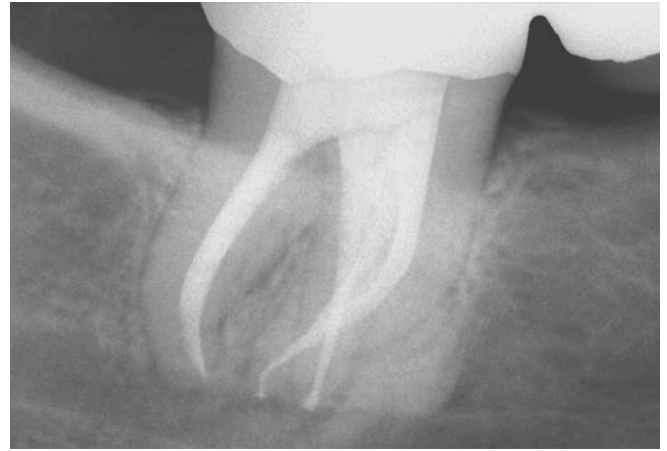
A recall radiograph demonstrates the revisional endodontic treatment, the displaced MLII system, and the new restorative effort.
